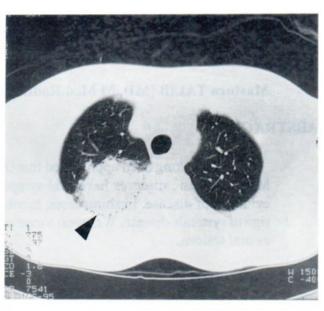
HRCT of the chest demonstrating a large non-cavitating opacity in the apical segment of the right upper lobe.
